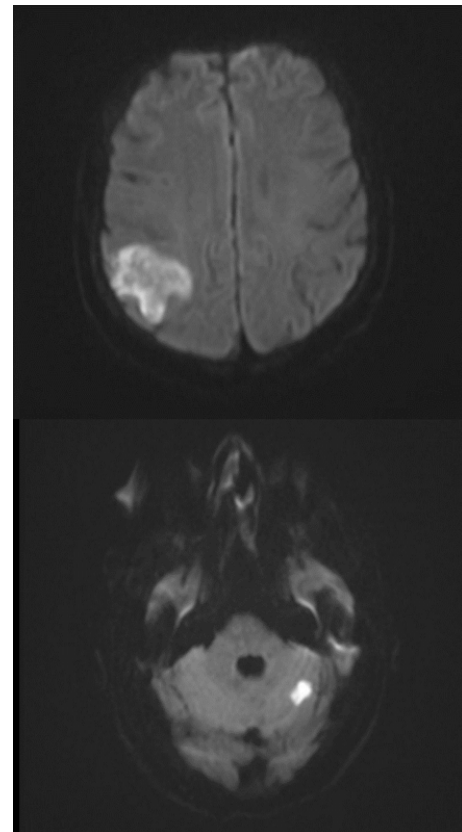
Diffusion MRI brain showing multifocal acute ischemia.
